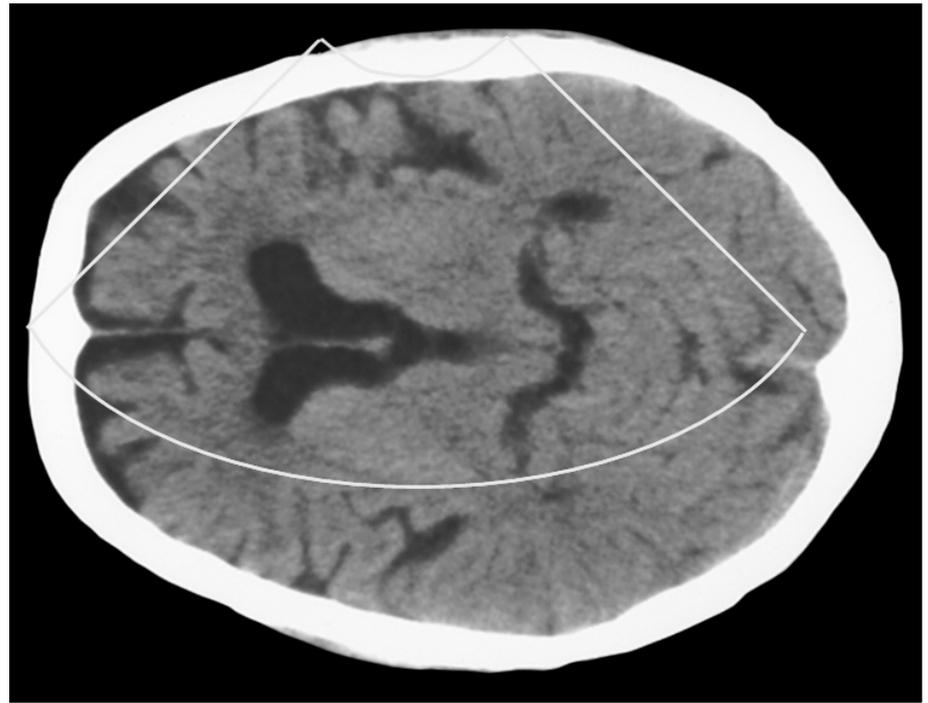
CT scan of the diencephalic imaging plane. The field of insonation is marked within the white lines. An US frame covers slightly more than one side of the brain in the dedicated imaging plane.
